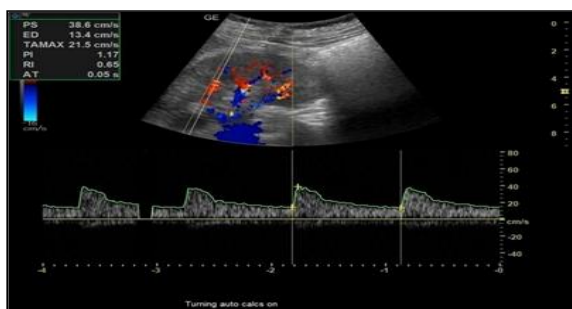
RI-0.65: Doppler image displaying wave pattern and different Doppler indices Patient name; SHABEERA BEGUM F/35 yrs
